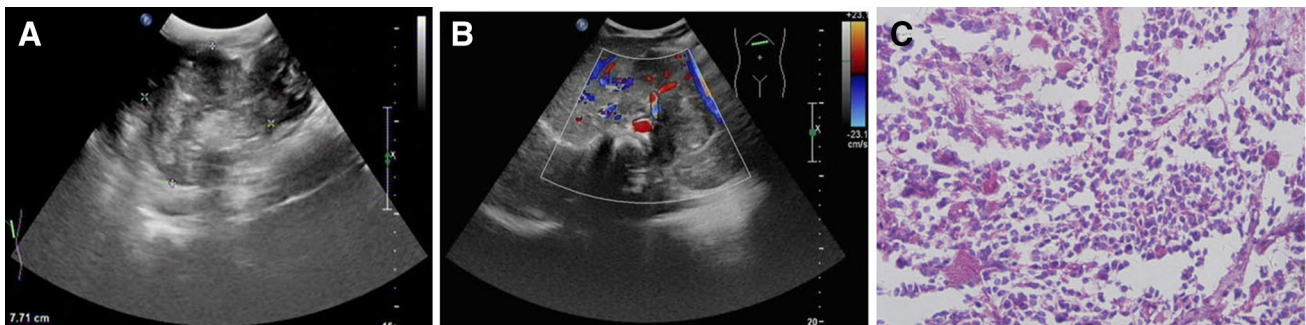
Ultrasound examination and biopsy of a patient (male, 3 years old) with ganglioneuroblastoma. a, b It showed the solid tumor located between the spleen and kidney and in the left upper abdomen, and the tumor was with inhomogenous echo, unclear border, patchy
